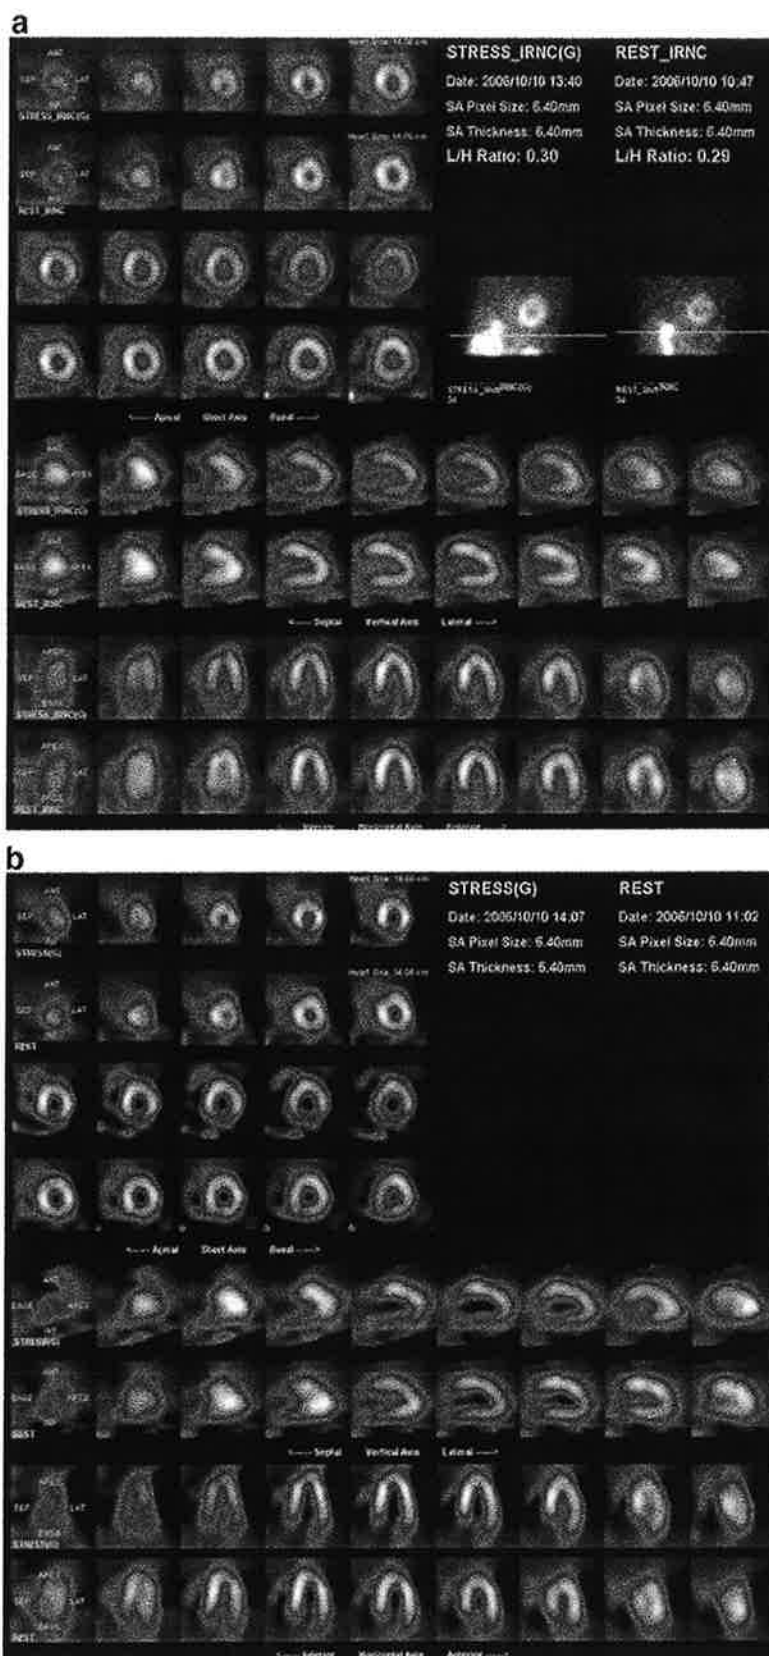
Comparison of myocardial perfusion stress (A) and rest (B) SPECT acquired "full-time" and processed with FBP (top row), compared to "half-time" SPECT processed with Evolution[®] software (bottom row), incorporating OSEM iterative reconstruction and resolution recovery. A single-day rest/stress 9/32 mCi Tc-99m sestamibi protocol was used. Image quality and resolution of the fixed anterior perfusion defect in this patient with a documented prior myocardial infarction is equivalent using the "full-time" and "half-time" acquisition and processing techniques. Courtesy Gordon DePuey, St. Luke's-Roosevelt Hospital, New York, NY.
